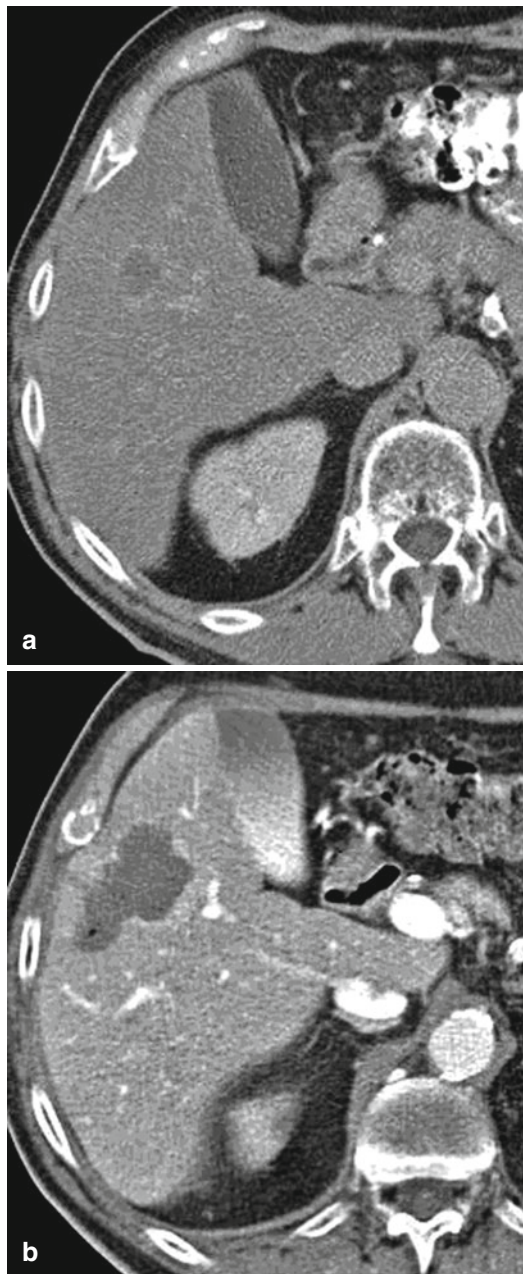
CT scan prior and 24 h post-RF ablation of a recurrent unifocal liver metastasis of colorectal cancer. Contrast-enhanced portovenous CT scan delineates unifocal recurrent liver metastasis in segment 5 of the liver (a; *arrow*). Contrast-enhanced portovenous CT scan 24 h post-RF ablation shows a clear demarcation of the RF ablation zone (b; *short arrows*) with typical small hyperdense rim encompassing the former tumor nodule (*long arrow*)
